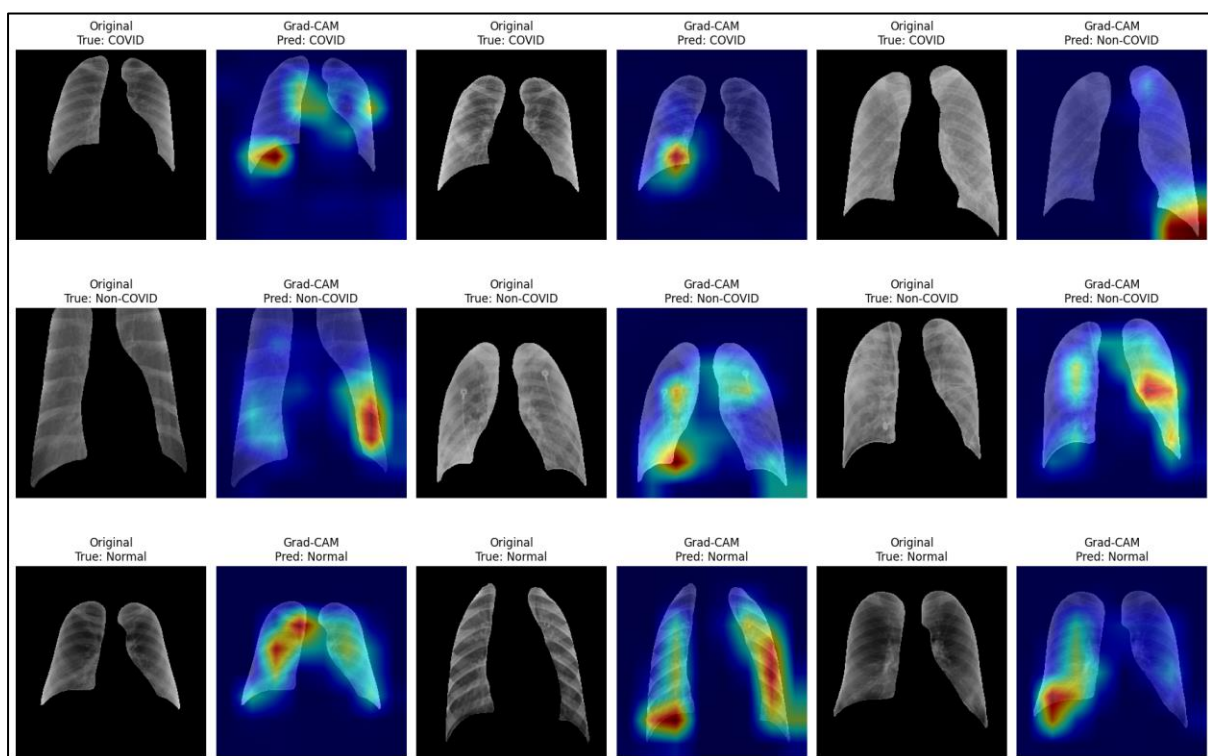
Grad-CAM Visualisation for CNN ResNet-50 Model Predictions on Chest X-rays.
